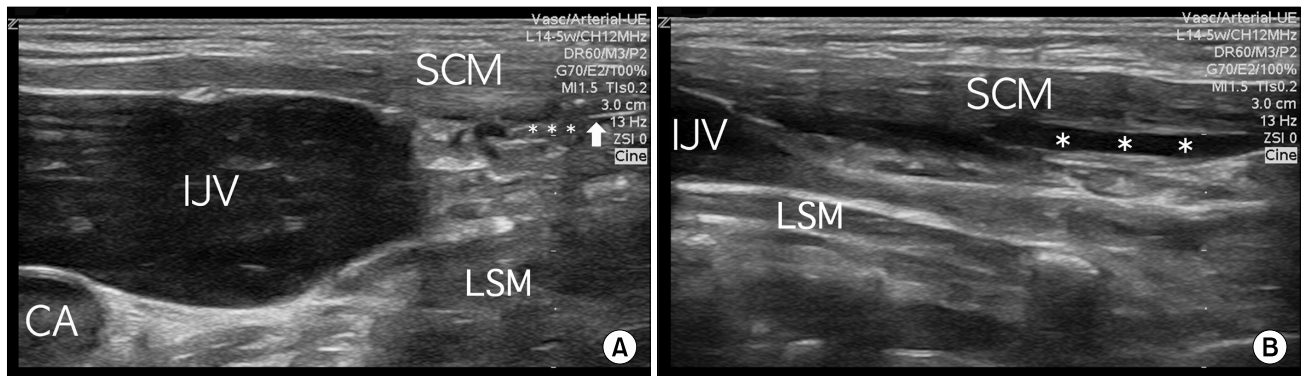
(A) A 10 MHz linear transducer was positioned at the intersection of the SCM and external jugular vein in transverse position. Survey ultrasound scan showing the SCM, CA, IJV, and LSM. A 25-gauge, 2.54-cm needle (arrow) connected to a 10 ml syringe containing local anesthetic was advanced to the posterior border of the SCM muscle with penetration of the investing cervical fascia (asterisk). The right IJV was dilated to compensate for the left thrombotic IJV. (B) The transducer was then moved along the posterior border of the SCM vertically, and a total of 10 ml of local anesthetic was injected (asterisk) in a caudad and cephalad direction at the posterior border of the SCM. CA: Carotid artery, IJV: Internal jugular vein, LSM: Levator scapulae muscle, SCM: Sternocleidomastoid muscle.
